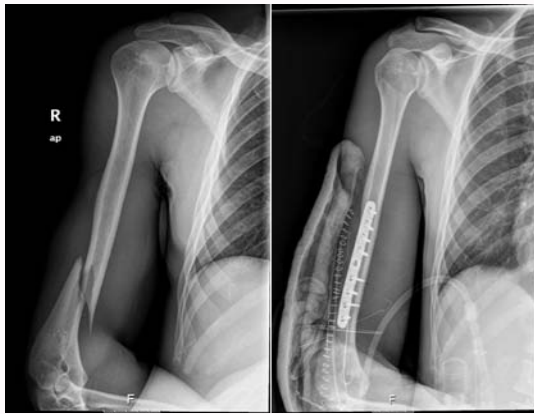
X-rays of the elbow and arm that showed spiral fracture of the distal third of the humerus.
